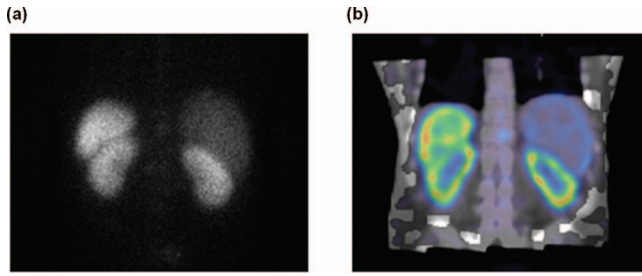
Posterior planar image (a) and fused coronal SPECT/CT slice (b) of the patient 24 h post-injection of ^{111}In -DTPA-Octreotide (185 MBq) showing high uptake in renal cortex and spleen.
